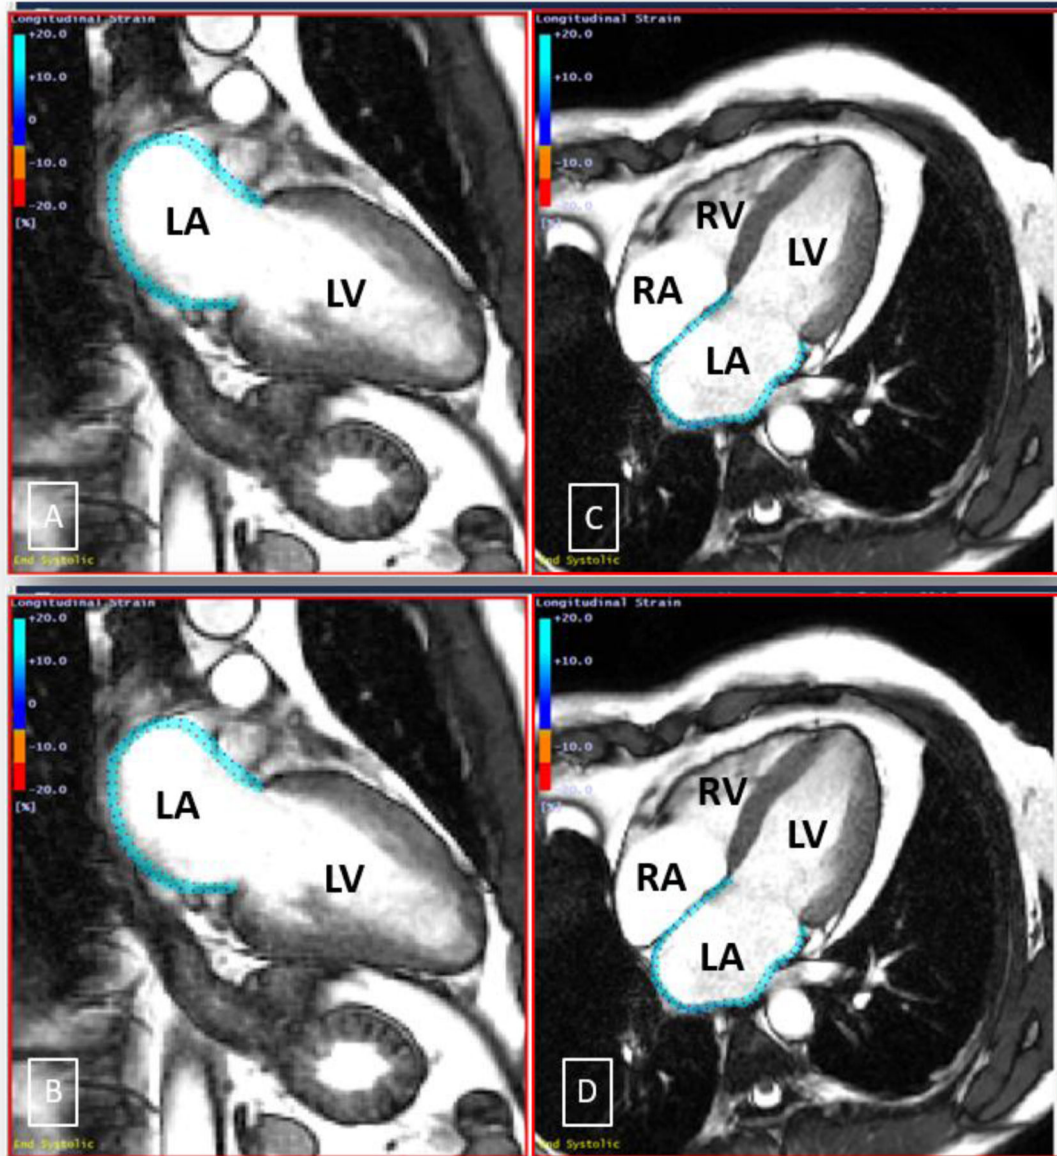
Multimodality feature tracking cardiac magnetic resonance imaging: (A) End-systolic 2-chamber view, (B) End-diastolic 2-chamber view, (C) End-systolic 4-chamber view, and (D) End-diastolic 4-chamber view.
